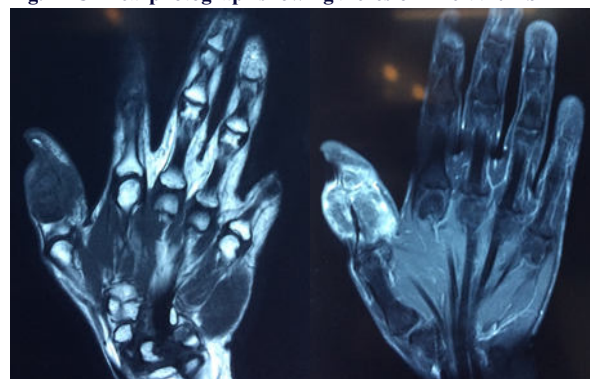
Contrast MRI pictures showing the lesion
